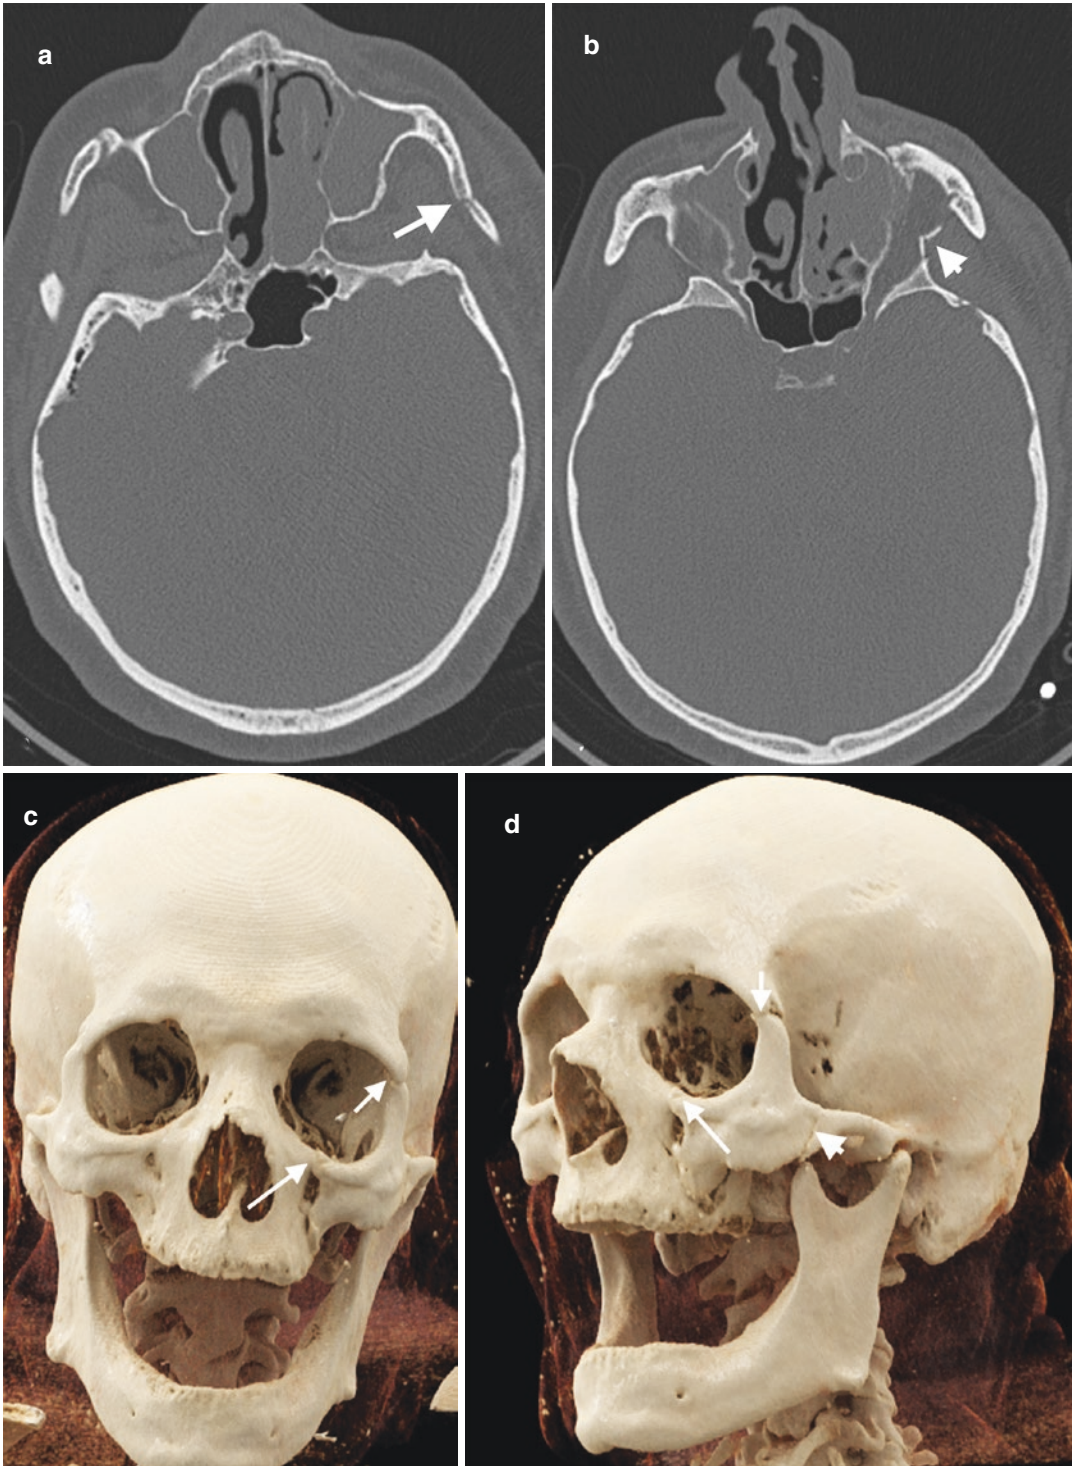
Fracture of ZMC complex in a 56-year-old man after MVA. (a) Axial CT image shows left zygomatic arch (arrow) fracture. (b) Axial CT image of the same patient reveals a fracture (arrowhead) involving zygomaticosphenoid
